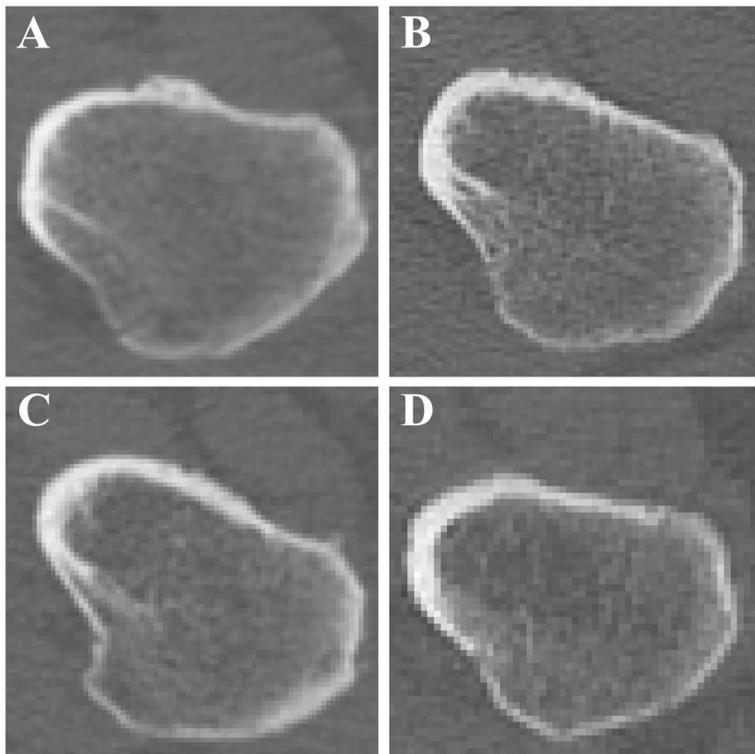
Horizontal CT-slice observation of the femoral calcar. Septum-type (A); Spur-type (B); Ridge-type (C); Femoral calcar not found (D). CT, computed tomography.
